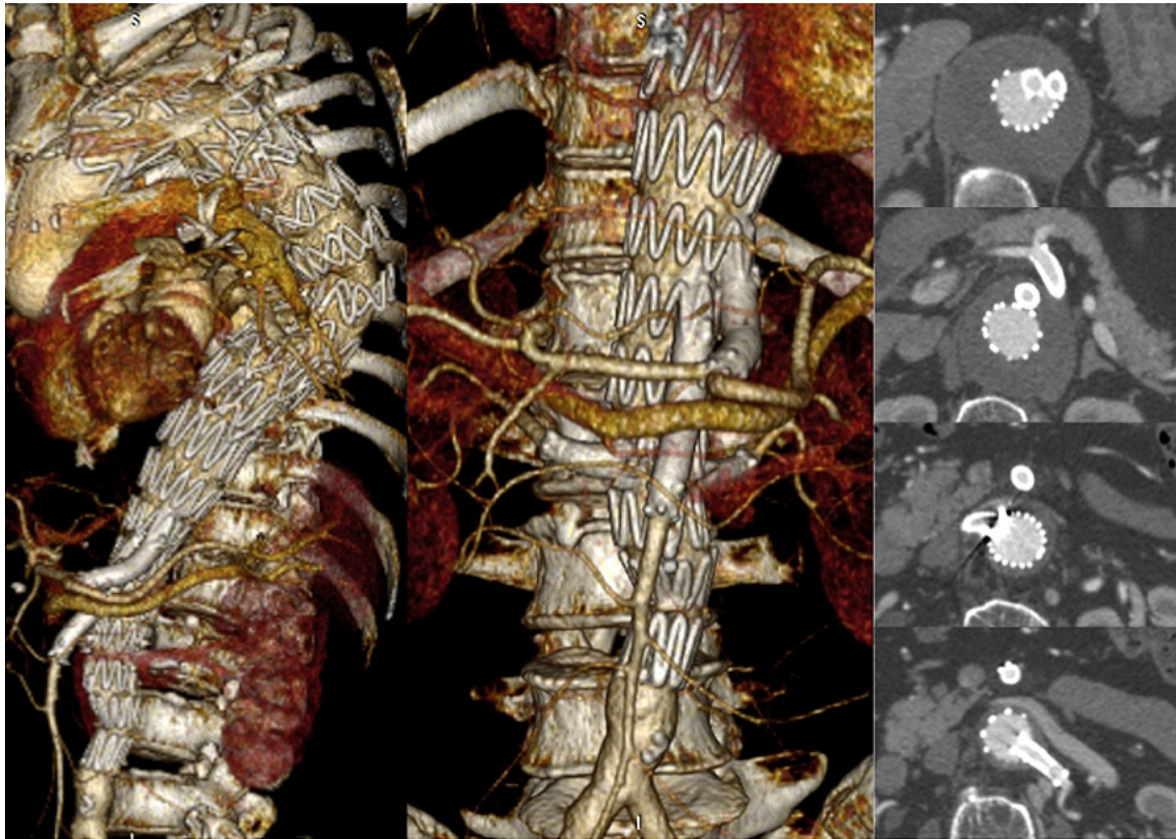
Computed Tomography after F/B-EVAR
